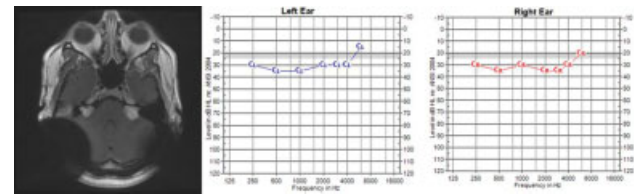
Axial T1 postcontrast MRI with artifact suppression and cochlear implant only audiometry for a patient with neurofibromatosis type 2 who underwent bilateral sequential cochlear implantation after L sided SRS and R sided surgery and SRS. The patient enjoys open-set speech understanding with both implants. MRI, magnetic resonance imaging; SRS, stereotactic radiosurgery.
